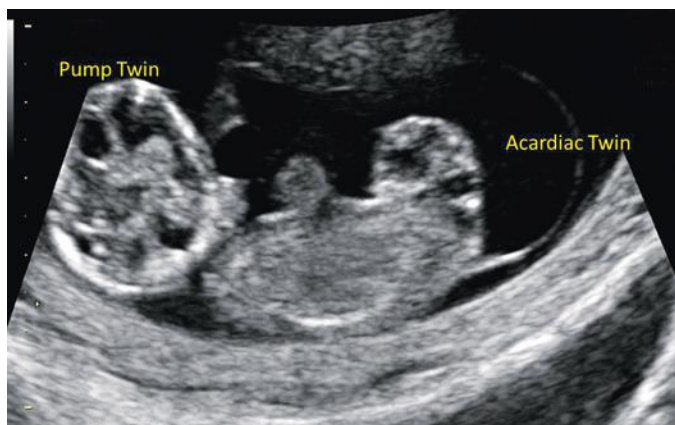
Longitudinal ultrasound image shows abnormal upper body development of the anomalous acardiac twin, which lacked demonstrable cardiac activity despite continued growth. The image includes an axial view through the brain of the morphologically normal pump twin.
